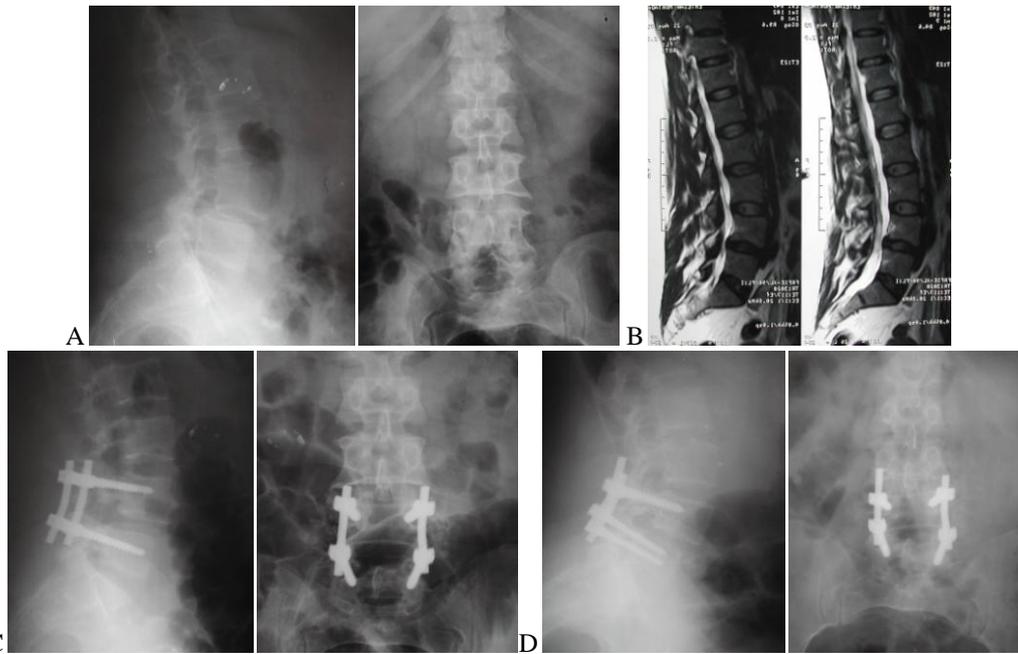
Shows radiology of a 60 years old female patient, her body mass index was 34.6, she has lytic spondylolisthesis L4-L5. Surgery done on January 2016 Preoperative ODI was 50 and at last follow up was 20. A- Preoperative X-rays. B- Preoperative MRI. C- Postoperative X-rays. D- 12 months postoperative X-rays.
